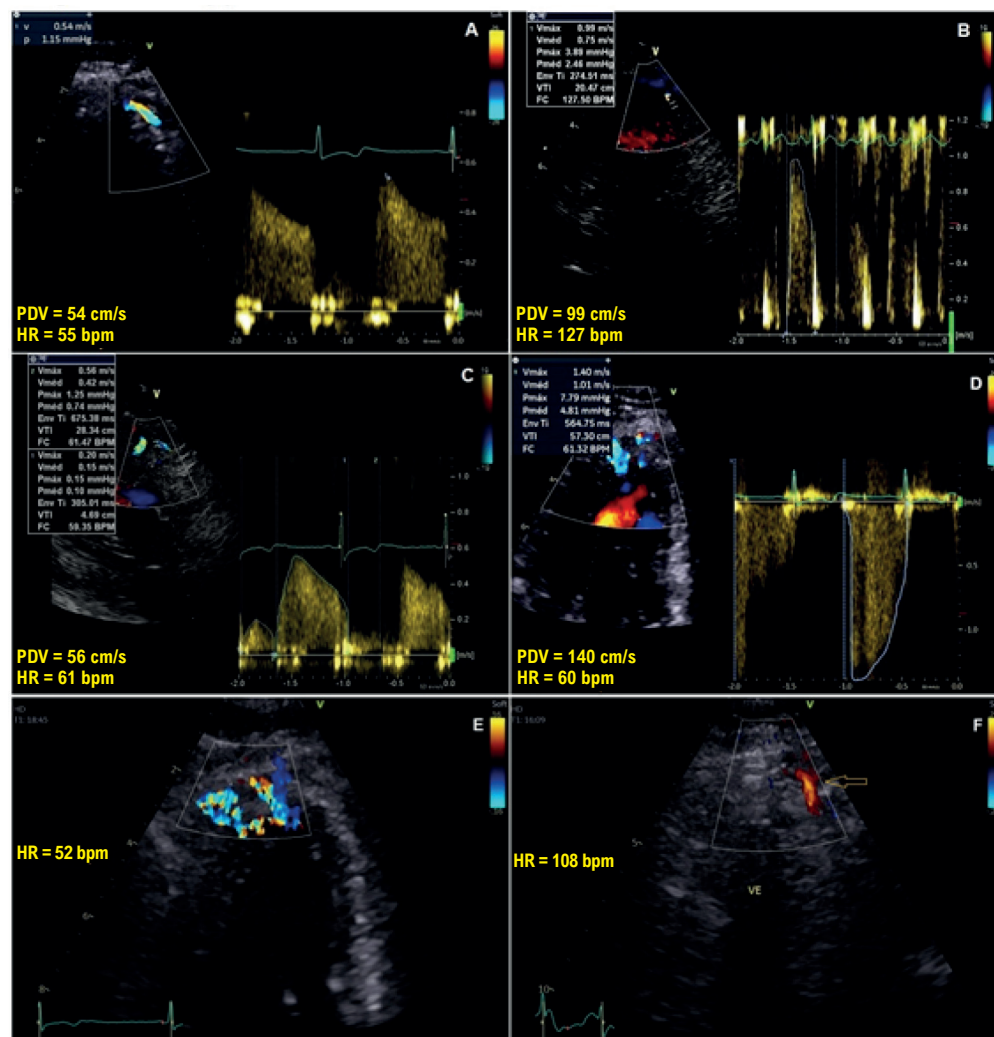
Pulsed-wave Doppler echocardiography of the LAD at baseline (A) and during dobutamine stress (B). Baseline pulsed-wave Doppler measurements in the LAD (C) and the microfistula (D). Prominent color Doppler flow through the microfistulas into the LV at baseline (E) is completely suppressed by the positive inotropic effect during physical exertion, whereas flow in the LAD (arrow) is preserved (F). HR: heart rate; PDV: peak diastolic velocity.
